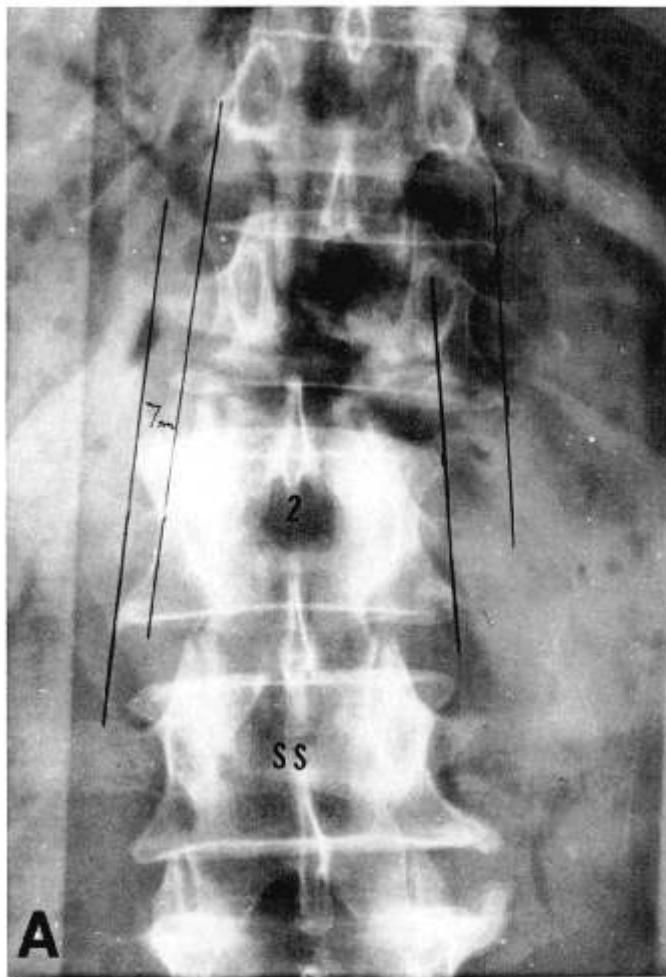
AP radiograph of the lumbar spine on the scoop stretcher reveals a 7-mm lateral displacement with no distraction or angular displacement.
